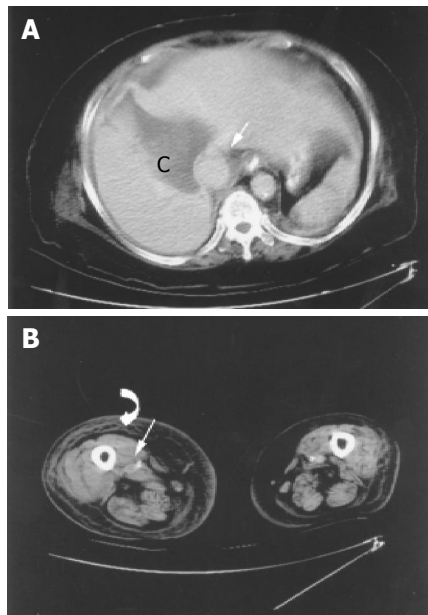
A: The post-drainage follow-up CT scan shows remarkable shrinkage of the hepatic cyst (C), no thrombi of IVC at this level (straight arrow). B: However, there is still long segmental thrombi occupation of lower trunk of IVC and right lower leg, including right popliteal vein (straight arrow) and subcutaneous tissue swelling of lower extremity due to cellulitis (curve arrow).
